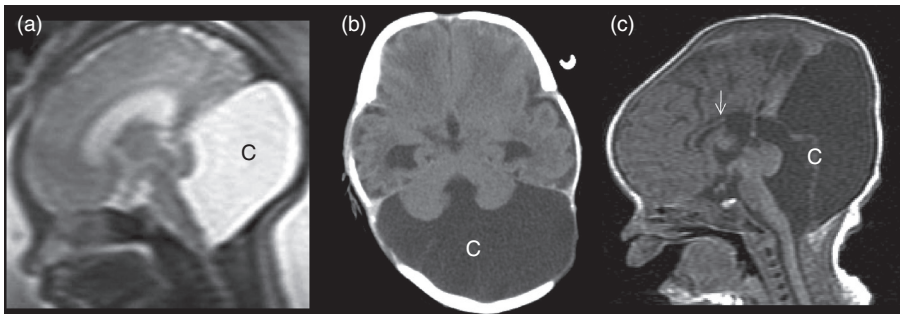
Dandy-Walker cyst (C): (a) fetal sagittal T2 MRI; (b) neonatal axial CT; (c) sagittal T1 MRI with hypogenesis of the corpus callosum (arrow).
